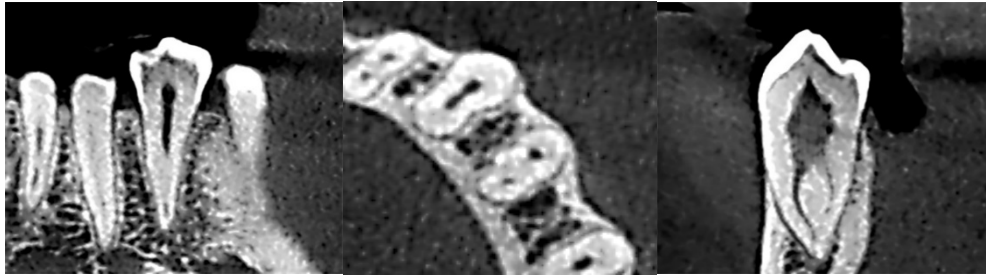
A) The coronal plane of CBCT of mandibular first premolar; B) The axial plane of CBCT image; C) The sagittal plane of CBCT image
